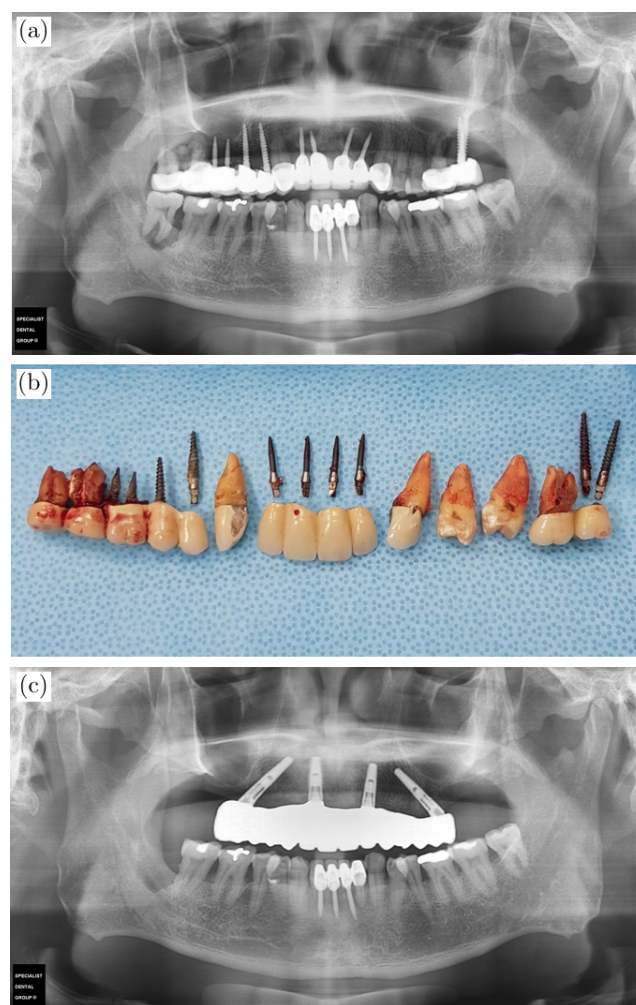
Maxillary arch MDI failure in a male patient approximately 5 years following placement. (a) Dental panoramic radiograph showing generalised severe peri-implantitis and bone loss. (b) Maxillary full arch dental clearance (note the excessive splinting and use of fixtures). (c) Dental panoramic radiograph shows that the Nobel BioCare All-on-4® implant system replaces the previous 10 maxillary arch MDI.
